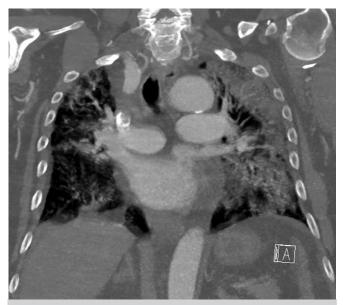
Diagnostic images. Computed tomography scan of the chest demonstrating extensive peripheral patchy ground-glass opacities throughout bilateral lungs.
